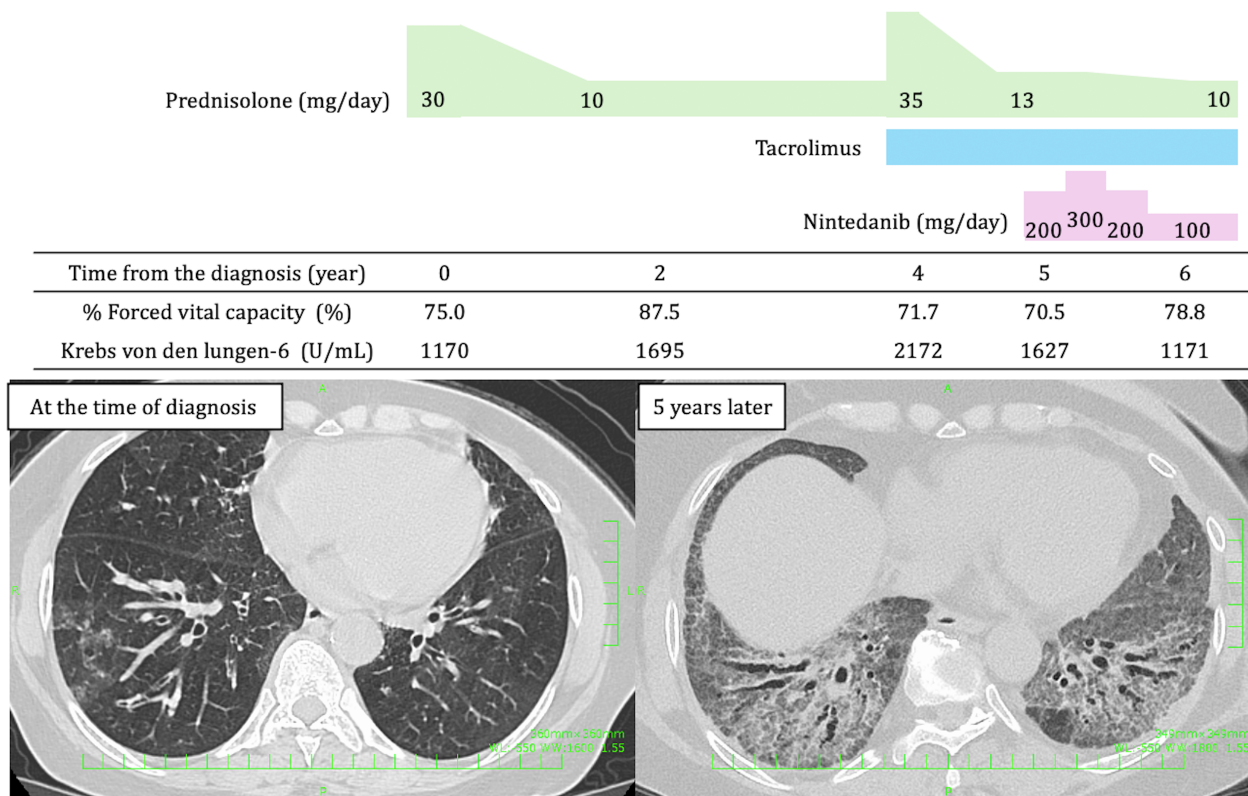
Clinical course and findings of the chest computed tomography of Case 2. High-resolution computed tomography (HRCT) of the chest at diagnosis shows ground-glass opacity (GGO) in both lungs, a finding consistent with cellular nonspecific interstitial pneumonia (NSIP). HRCT of the chest obtained at the start of nintedanib administration (5 years after diagnosis) shows interstitial reticulation, GGO, and traction bronchiectasis, findings that are consistent with fibrotic NSIP.
